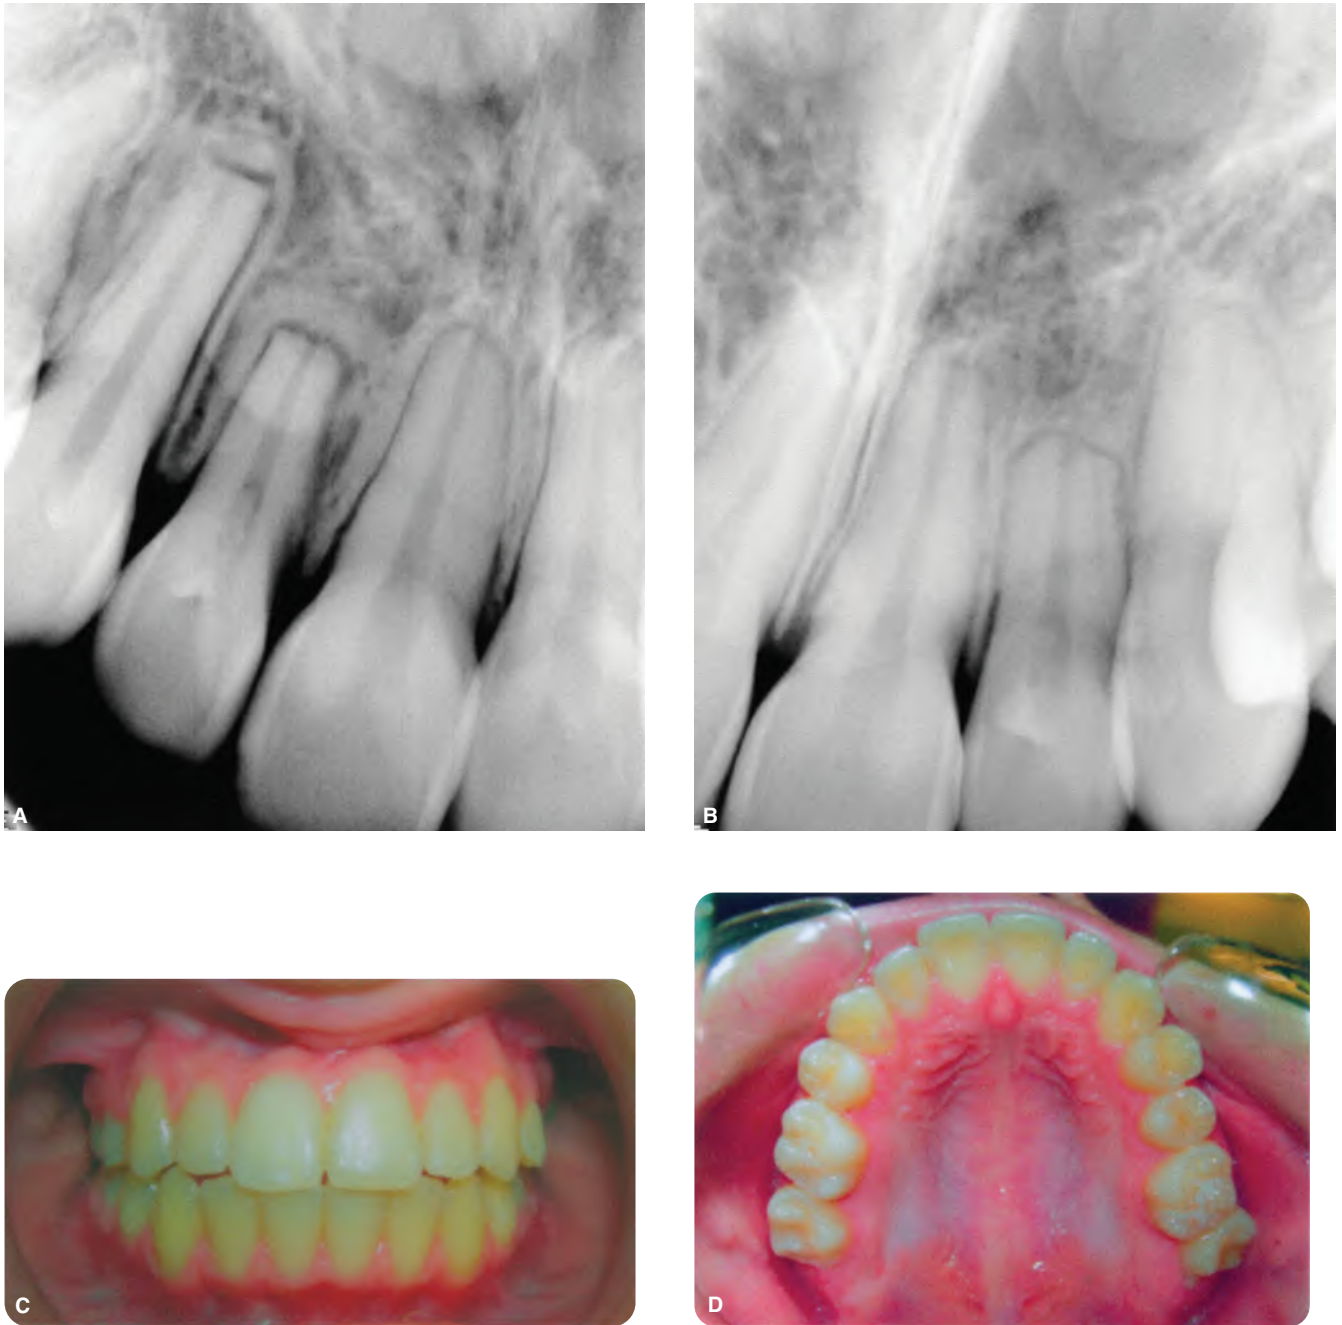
A & B. Right and left radiographic views of a 15-year-old female who had undergone OTM for 3 years. Significant resorption is evident on all maxillary incisors. Also of note is the increased bone density and width of the lamina dura around the blunted root apices along with the build of calcification in the coronal aspect of the two lateral incisors that may indicate pulp degenerative changes. C & D. No discoloration of the crowns is present. (Courtesy of Dr. Kathleen M. Valencia, Weston, Florida, U.S.A. [Radiographs and photographs].)
